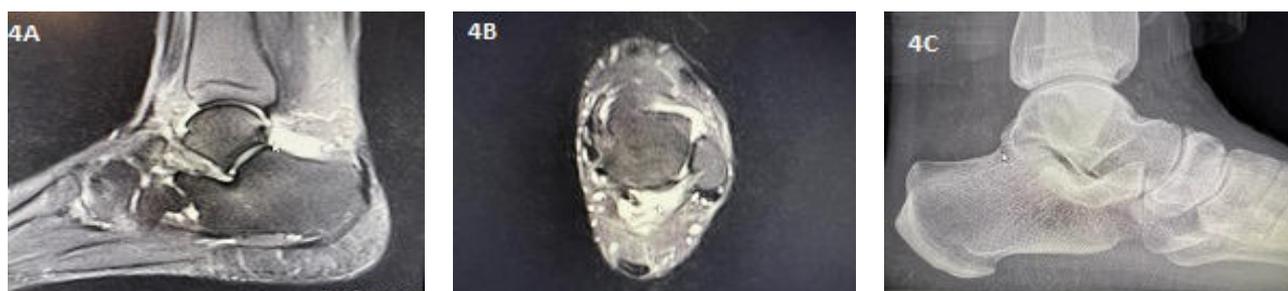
(A) FHL effusion grade and localization (white arrow) in the ankle sagittal MR section after PAA. (B) FHL effusion degree and localization (white arrow) on ankle axial MR section after PAA. (C) Excision of the OT on the lateral radiograph of the pressing foot at the last follow-up after PAA (white arrow).
